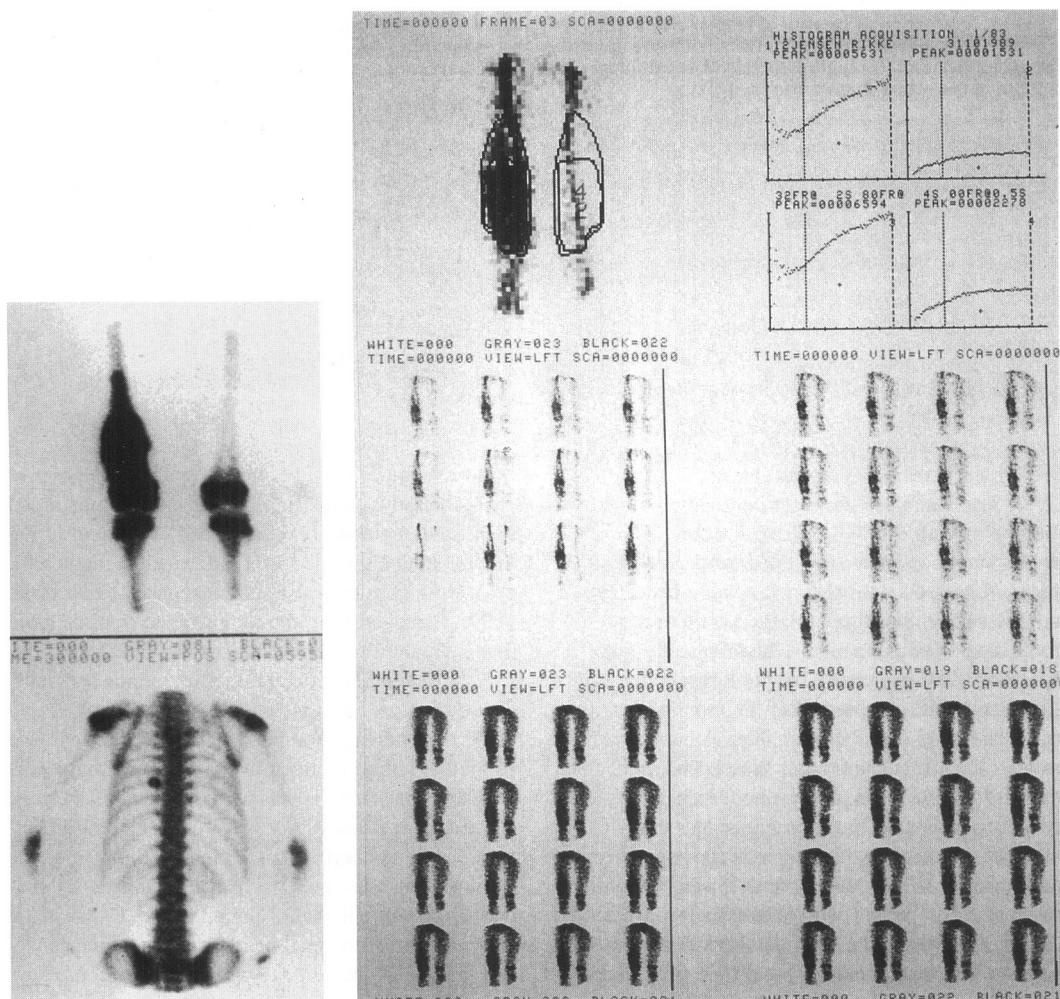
a. Bone scintigraphy in a 6-year-old girl with osteosarcoma in the distal end of the right femur and a metastatic lesion in the 7<sup>th</sup> left rib.
